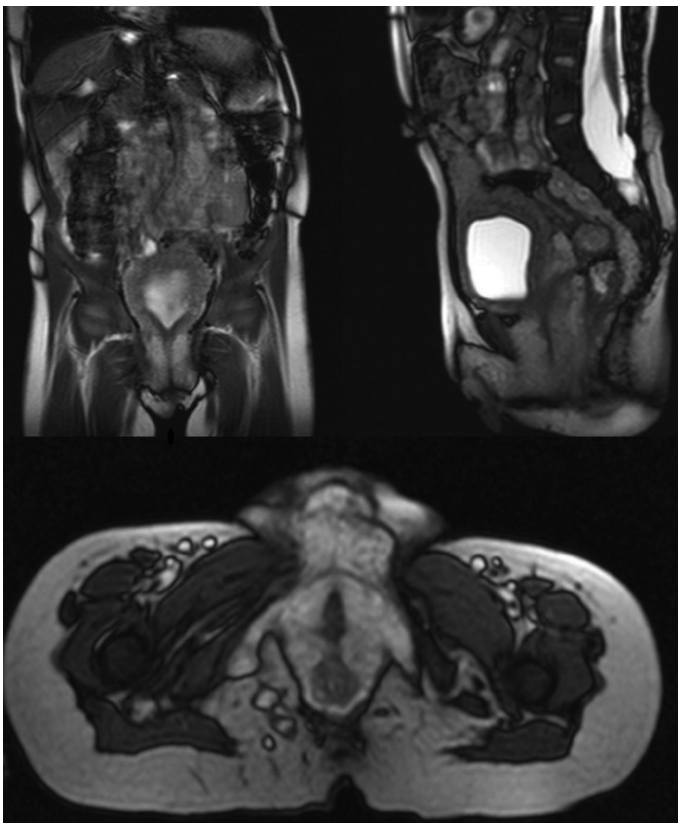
Magnetic resonance imaging of abdomen and external genitalia: multiple plexiform neurofibromas filling the pelvic area with invasion of the sacral neural foraminae and subcutaneous region, multiple neurofibromas in the labium majus and the external genital area
